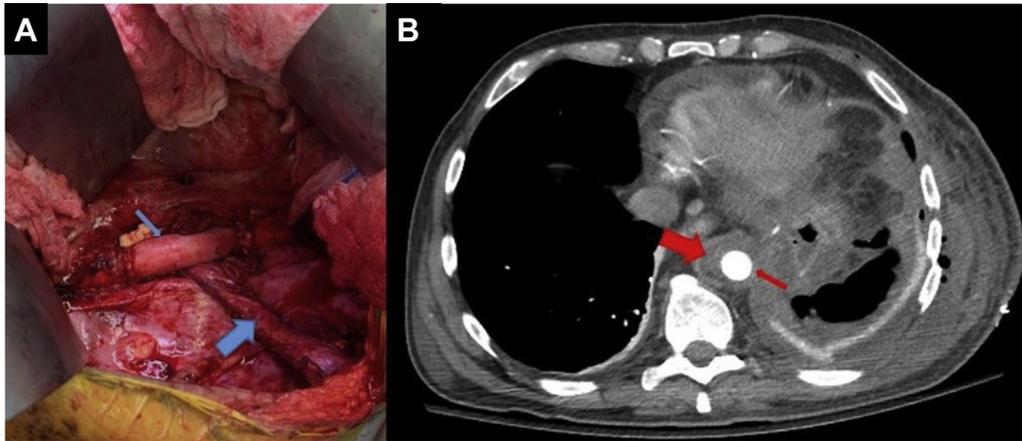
A, Sagittal view showing aortic CryoGraft (small arrow; CryoLife, Inc) and intercostal flap (large arrow). B, Postoperative computed tomography scan showing aortic CryoGraft (small arrow) and intercostal flap (large arrow).
